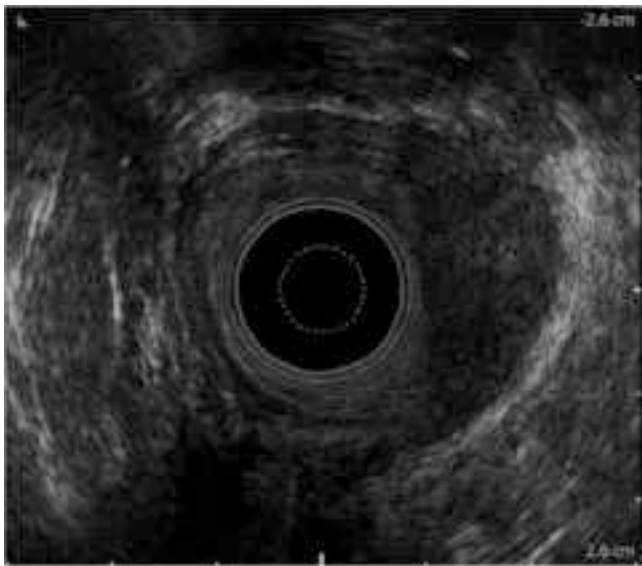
Transanal endoscopic ultrasound can be used to assess local staging of anal cancer.
